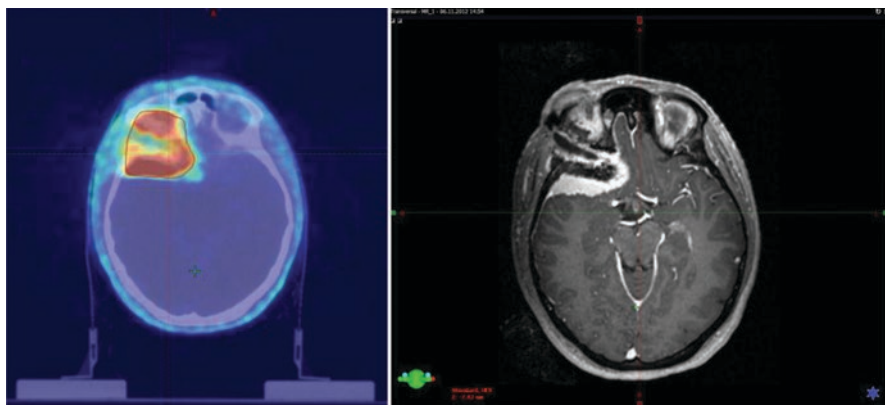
Planning ^{68}Ga -DOTATATE PET/CT (left) used for GTV (blue line) definition in a large right sphenoid wing meningioma. CE-T1 MRI does not define the tumour extension into the right orbit (right)
